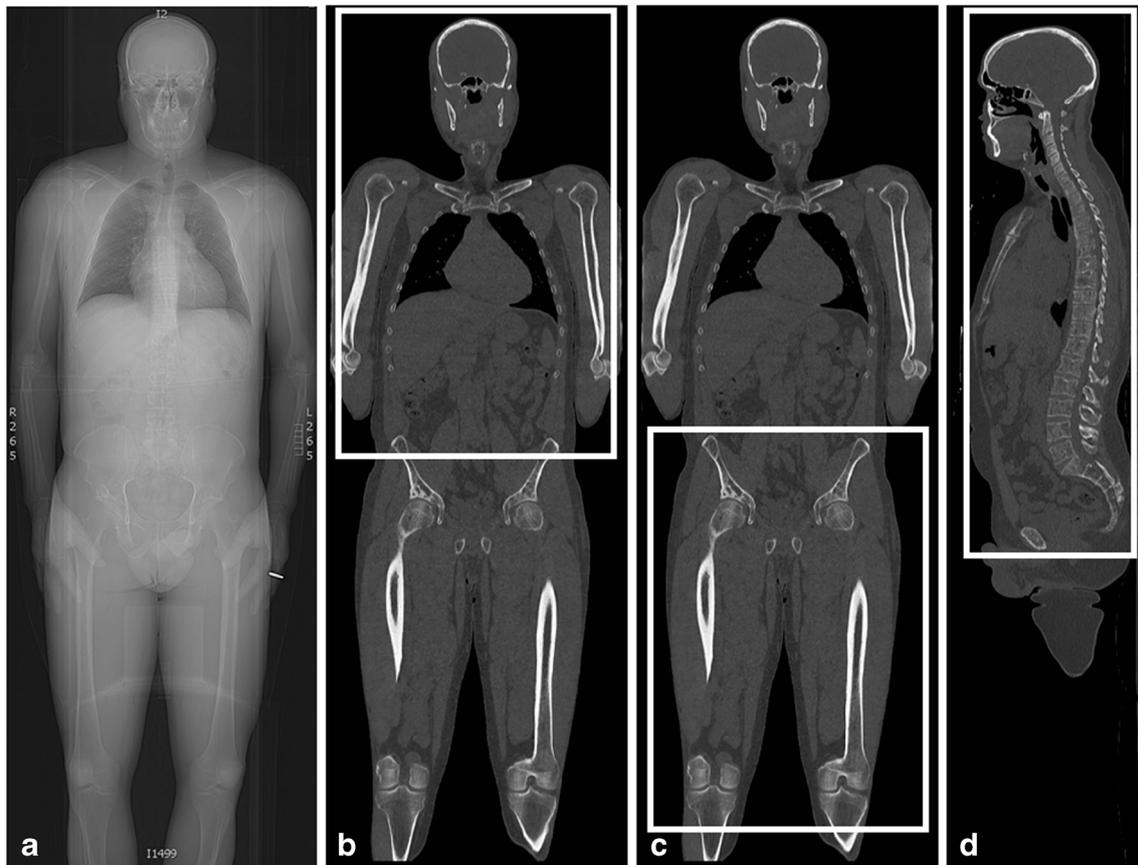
A 46-year-old man with multiple myeloma. a Frontal CT scout image demonstrates patient positioning for whole-body CT (WBCT) myeloma survey with arms down and hands over the pelvis or upper thighs. b Coronal reconstructed image of the entire body from the same patient
